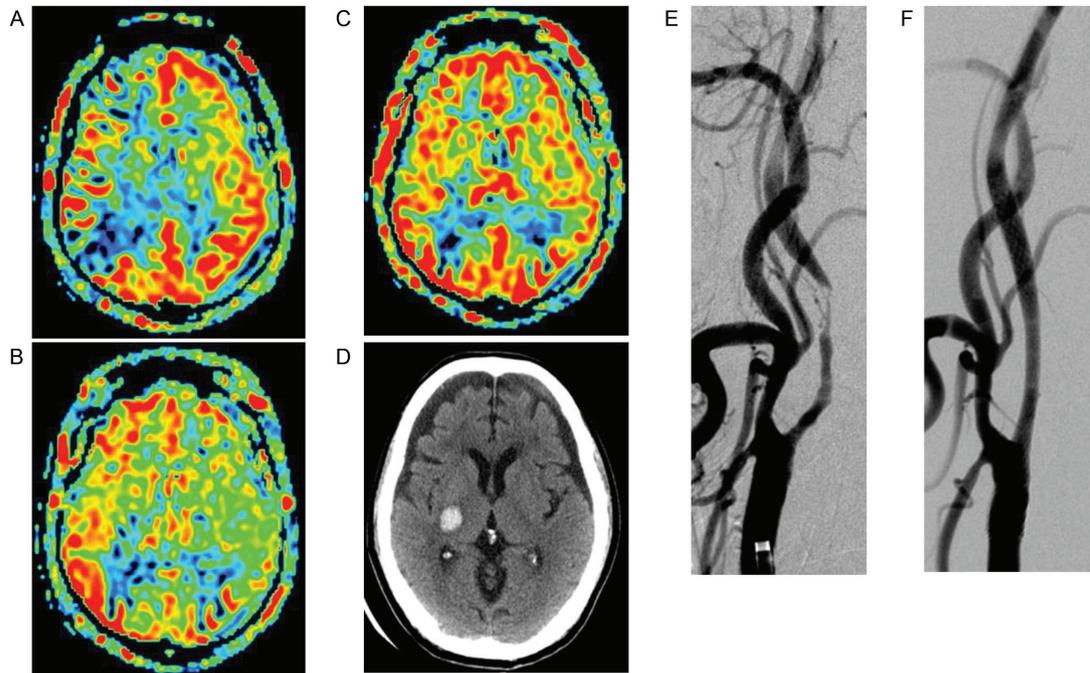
An 80-year-old male in whom ASL during the perioperative period after CAS facilitated HPS assessment. (A) Pre-operative ASL. (B) ASL the day after surgery CAS. (C) ASL 7 days after CAS. (D) Cephalic CT the day after CAS revealed right internal capsule hemorrhage. (E) Preoperative cerebral angiography showed marked stenosis of the right internal carotid artery. (F) Postoperative cerebral angiography confirmed the reduction of internal carotid artery stenosis. ASL: arterial spin labeling; CAS: carotid artery stenting; HPS: hyperperfusion syndrome
